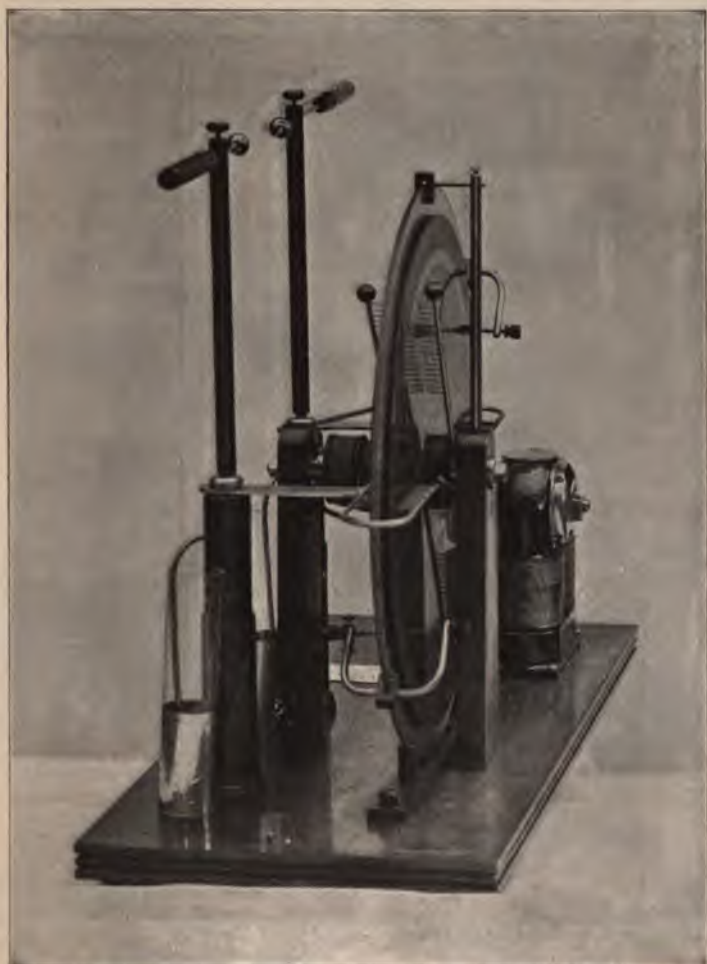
Static Apparatus for Operating X-Ray Tubes.
